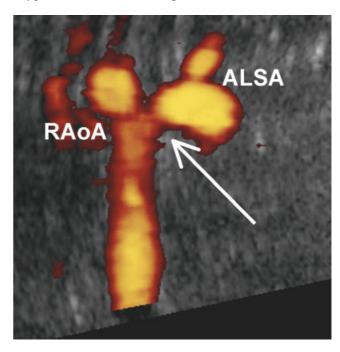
Power Doppler ultrasound image showing the frontal view of the descending aorta with the right aortic arch (RAoA) with Kommerell's diverticulum (arrow) and aberrant left subclavian artery (ALSA). (Same projection as the postnatal angiogram in Figure 2.)
